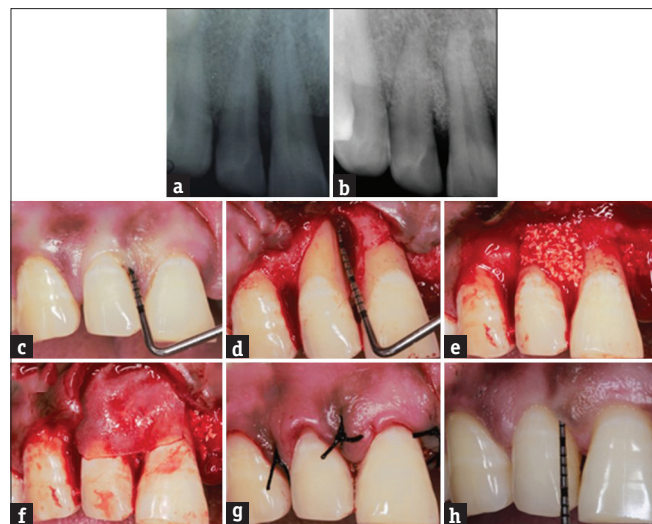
(a) preoperative radiograph showing interdental bone loss, (b) 6-month follow-up showing radiographic evidence of bone fill, (c) preoperative probing pocket depth of 9 mm, (d) moat type intrabony defect, (e) intrabony defect grafted with freeze-dried bone allograft, (f) biphasic cross-linked collagen membrane placed, (g) suturing, and (h) 6-month follow-up showing decrease in probing pocket depth to 3 mm
